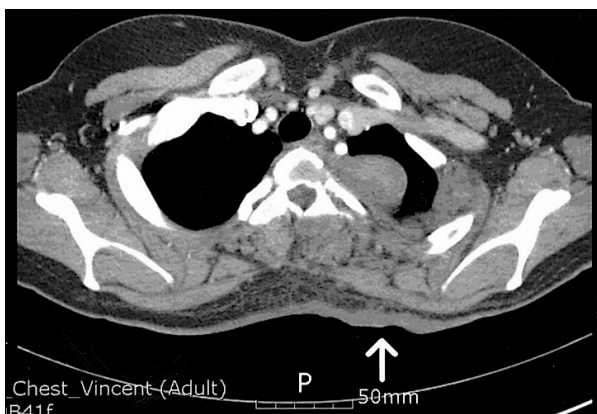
In the CT findings, multiple skin lesion of left sulci and a intrathoracic mass were found.
